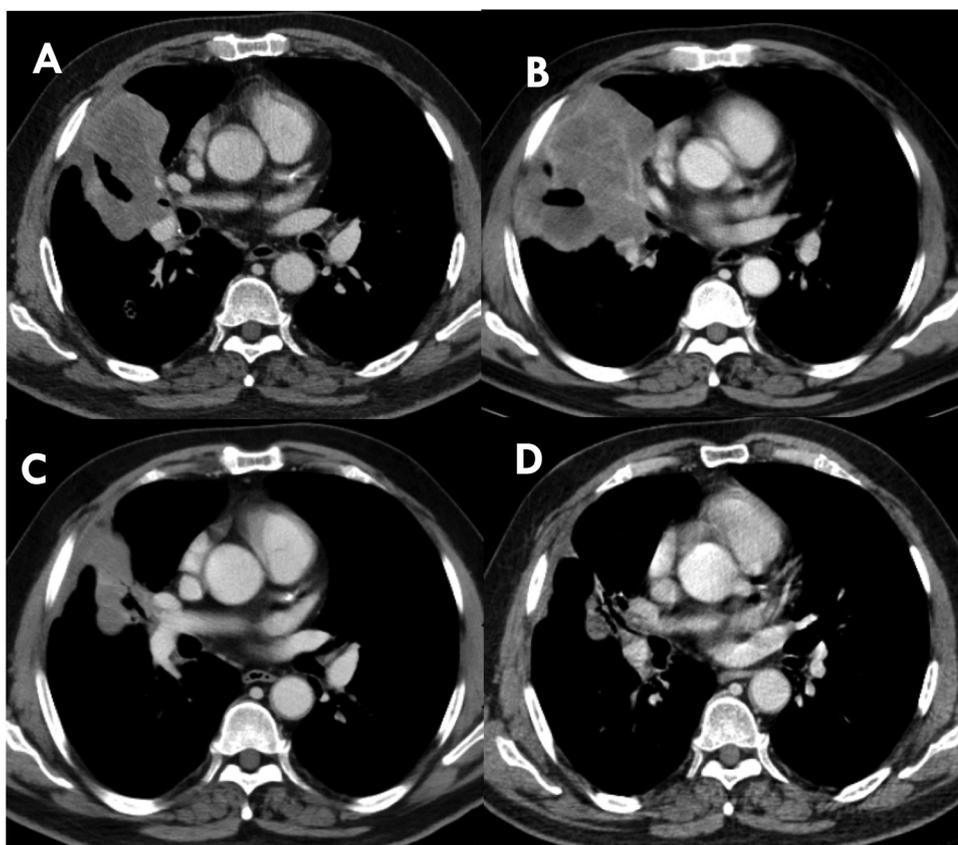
Axial computed tomography images of a patient with advanced non-small cell lung cancer harboring a concurrent epidermal growth factor receptor gene (EGFR) L858R mutation and MET amplification, (A) after chemotherapy, the CT scan displayed an enlarged right lung mass, (B) interval progression of disease after 4 weeks of single-agent gefitinib, (C) dramatic interval improvement in right lung mass thickening after 4 weeks of combination gefitinib and crizotinib, and (D) right lung lesion almost disappeared after 8 weeks of combination gefitinib and crizotinib.
